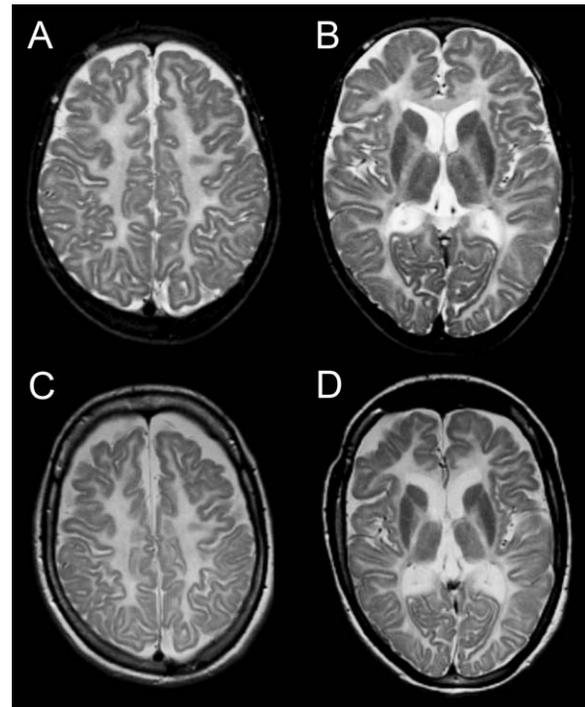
Global atrophy as shown on longitudinal magnetic resonance imaging. (A, B) Axial T₂-weighted images of an 8-year-old hypomyelination, hypodontia, and hypogonadotropic hypogonadism patient with a homozygous missense mutation in *POLR3A*. (C, D) Severe global atrophy is visible in the same patient at the age of 19 years, manifested both by an increased volume of cerebrospinal fluid spaces and by a decreased intracranial volume (thicker skull).
